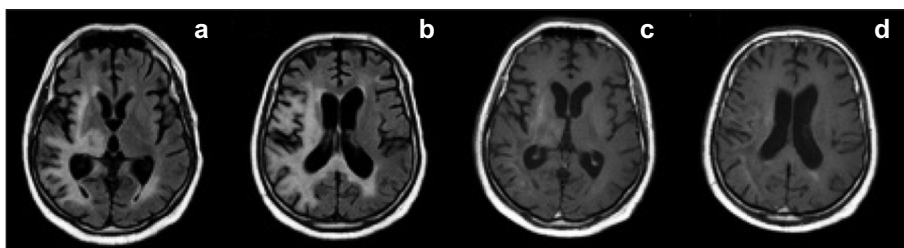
MRI scans obtained 3 weeks after PLEX (June 1, 2014); axial FLAIR images (a, b, c) showed significant increased in signal intensity in the right fronto-parietal subcortical white matter and periventricular area with involvement of corpus callosum splenium, and small hyperintense signal abnormality in the left anterior frontal subcortical white matter. There was minimum mass effect on the right lateral ventricle. Axial T1 postgadolinium image (d) showed gadolinium enhancement in the right parietal subcortical white matter.
